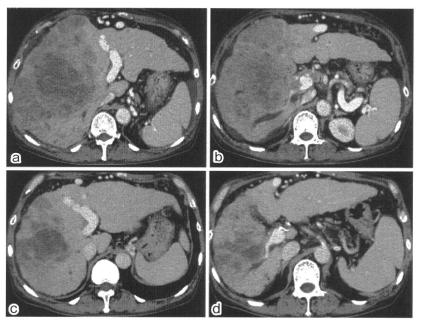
腹部造影 CT(初回治療終了後1カ月の直接治療効果度が TE3であった症例: A 群の1例) a)治療前: 肝右葉を中心に、内部に壊死をともなう辺縁不均一な巨大な肝細胞癌を認めた. 肝臓は腫瘍により腫大していた. b)治療前: 高度門脈腫瘍栓(Vp3・4)を認める. c)治療後: 3剤 one shot 肝動注 + low dose FP療法を1コース施行し、1カ月後の評価 CT. 肝細胞癌は著明に縮小し、肝の突出や腫大も改善している. d)治療後: 門脈腫瘍栓の退縮を認める.*治療前の腫瘍マーカーは AFP: 2410ng/ml/PIVKA-II: 12650mAU/mlであったが、治療後(腹部造影 CT と同時日に測定した結果)は AFP: 870ng/ml/PIVKA-II: 3870mAU/ml に低下していた.
